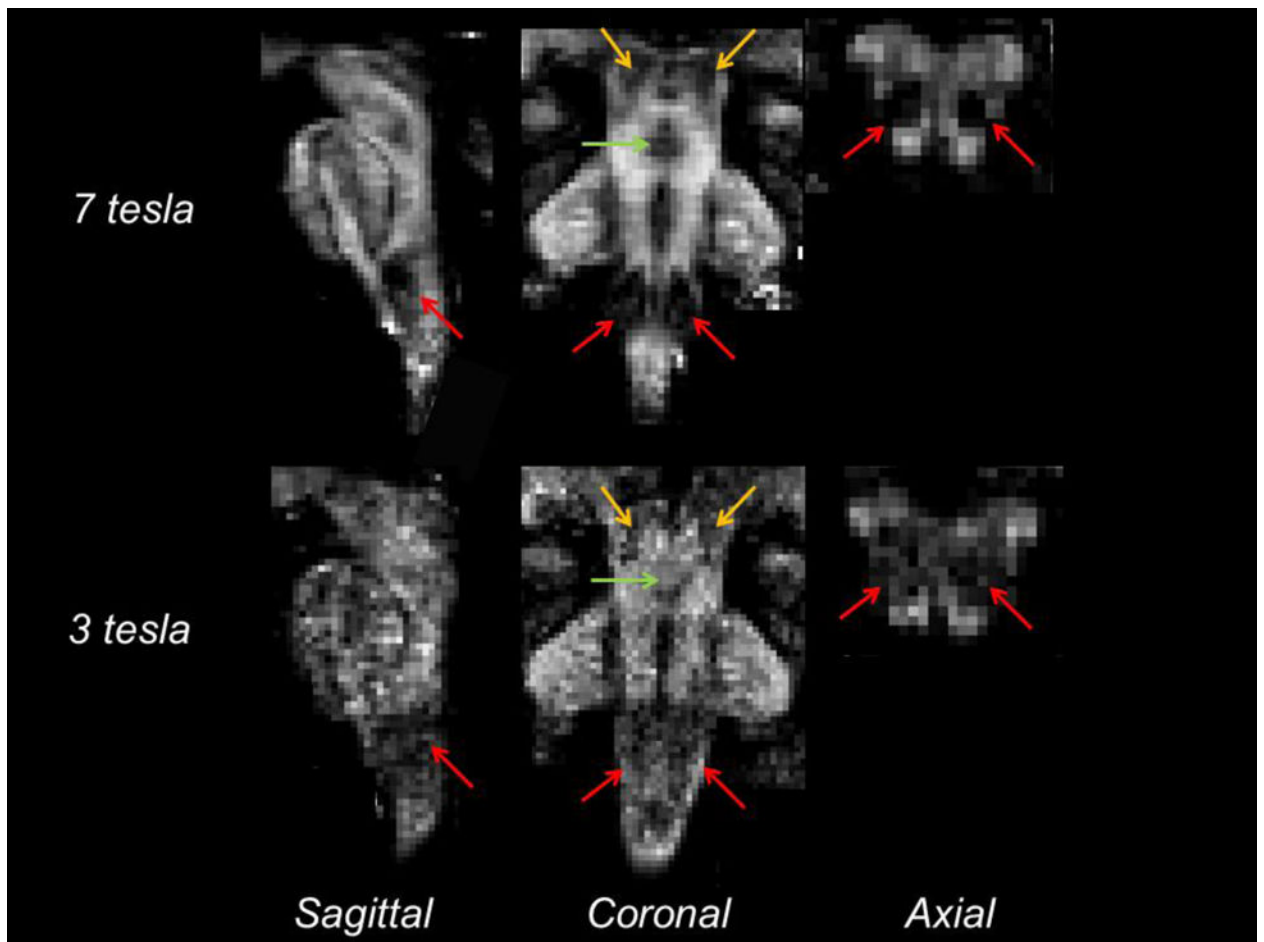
Sensitivity of structural MRI to visualize brainstem nuclei at 7 tesla and 3 tesla
